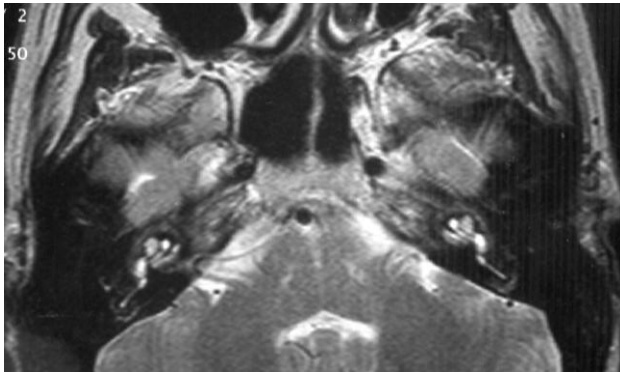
Preoperative MRI (T2 weighed) of the petrosal bone (transversal view): cochlea and labyrinth are both patent, on the right more eminent than the left side. There is a pericochlear high signal.
